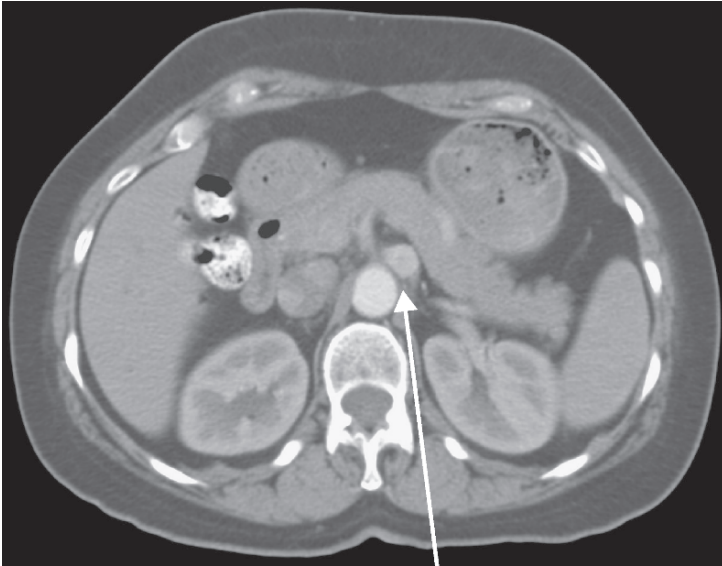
Extra-adrenal pheochromocytoma/paraganglioma. CT scan showing 2.2-cm-enhancing mass (arrow) anterolateral to the aorta consistent with an extra-adrenal paraganglioma
